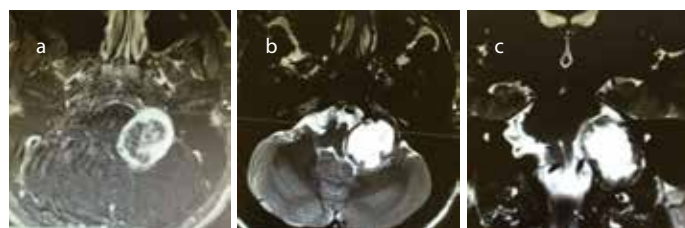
a-c. (a) T1-weighted transverse MRI image of tumor occupying pontocerebellar triangle (b) T1-weighted fat suppressed transverse MRI image of tumor occupying pontocerebellar triangle and jugular foramen. (c) T2-weighted coronal MRI image of tumor occupying pontocerebellar triangle extending through to the neck.
